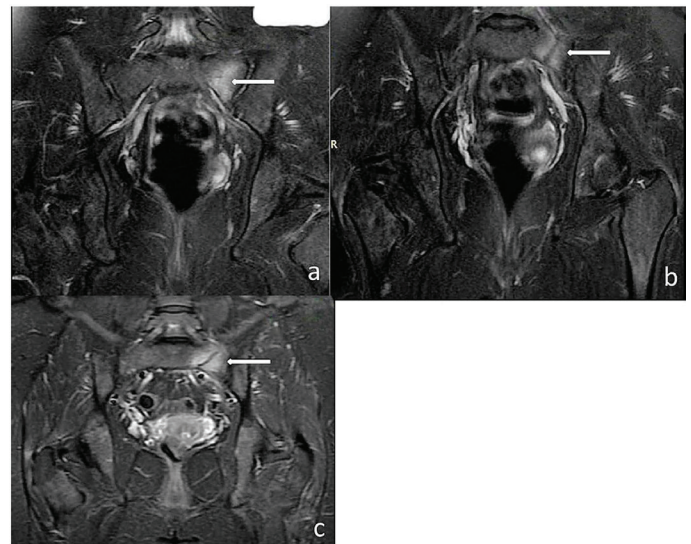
(a) Coronal T2 fr FSE FSat MRI of the sacrum showing bone marrow edema in the left sacrum (arrow). (b) Coronal fr FSE T2-weighted image demonstrating the fracture line in the left sacrum (arrow). (c) Coronal STIR image demonstrating the fracture line in the left sacrum (arrow)
